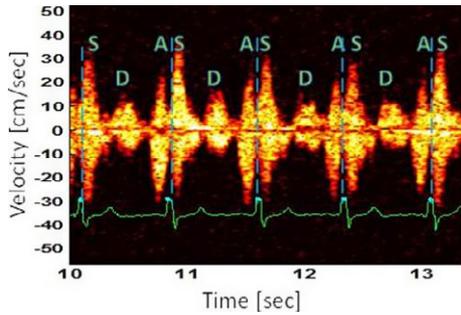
Typical LDS recorded from a subject with normal sinus rhythm using the TPD system. (transducer placed at the 4th intercostal space, 5 cm to the right of the mid-sternal line). LDS = lung Doppler signals; TPD = Transthoracic Parametric Doppler.
